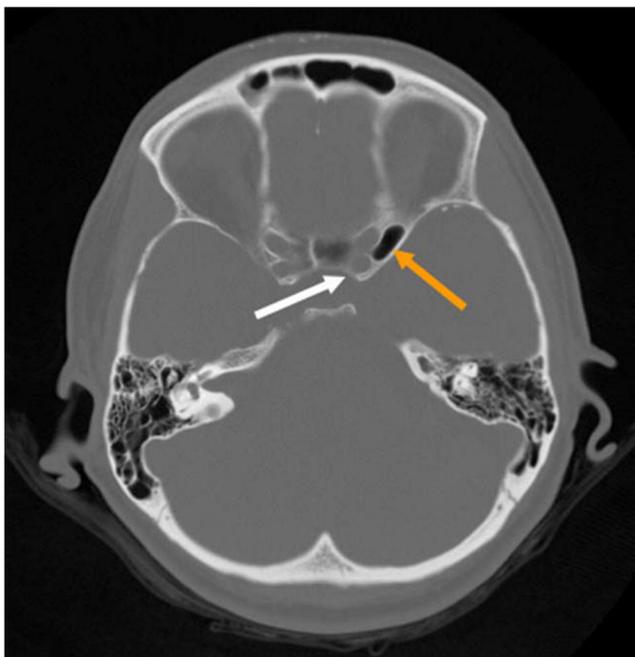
Pneumatized clinoid. A CT scan shows a subject with a pneumatized left anterior clinoid process (orange arrow). Note also that a complete caroticoclinoid foramen is also present (white arrow)
